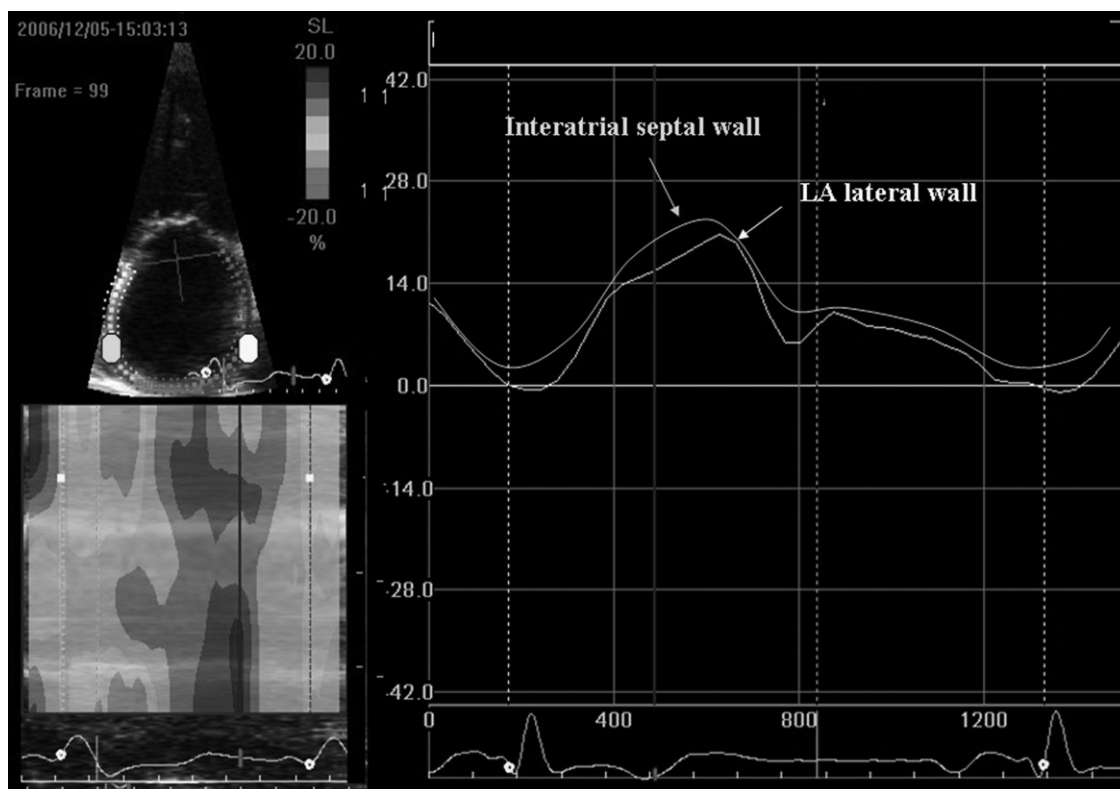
Two-dimensional strain curve of basal left atrial lateral wall and basal interatrial septal wall in a patient with idiopathic dilated cardiomyopathy from an apical four-chamber view. The curve is colour coded by the defined myocardial segment as depicted in the figure (yellow, basal lateral wall; green, interatrial septal wall). Note the severe impairment of LA deformation, with a peak of systolic strain of 19%. See Supplementary material online for a coloured version of this figure.
